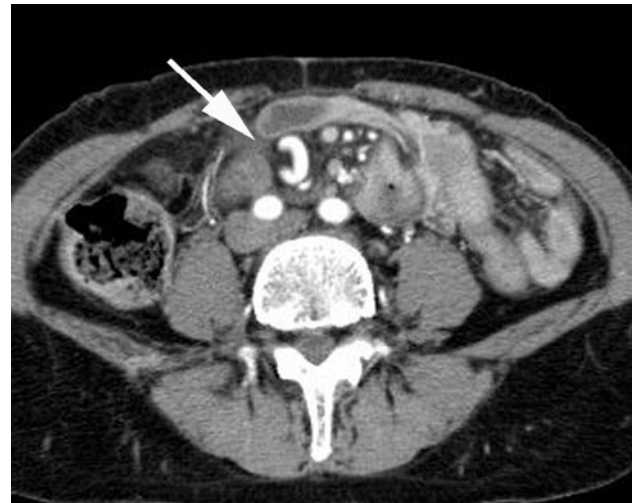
Early phase of an enhanced computed tomography (CT) scan showing twisting of the mesenteric artery (*arrow*) in a patient 269 days after laparoscopically assisted distal gastrectomy (LADG)
